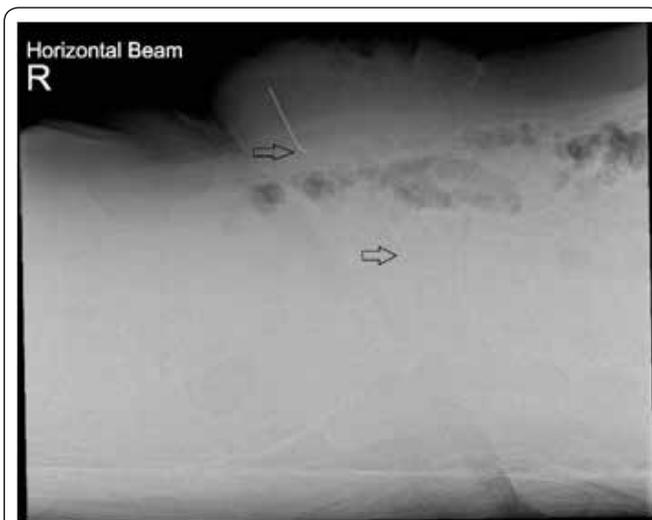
Lateral abdominal X-Ray demonstrating the same foreign bodies in the subcutaneous fat.
